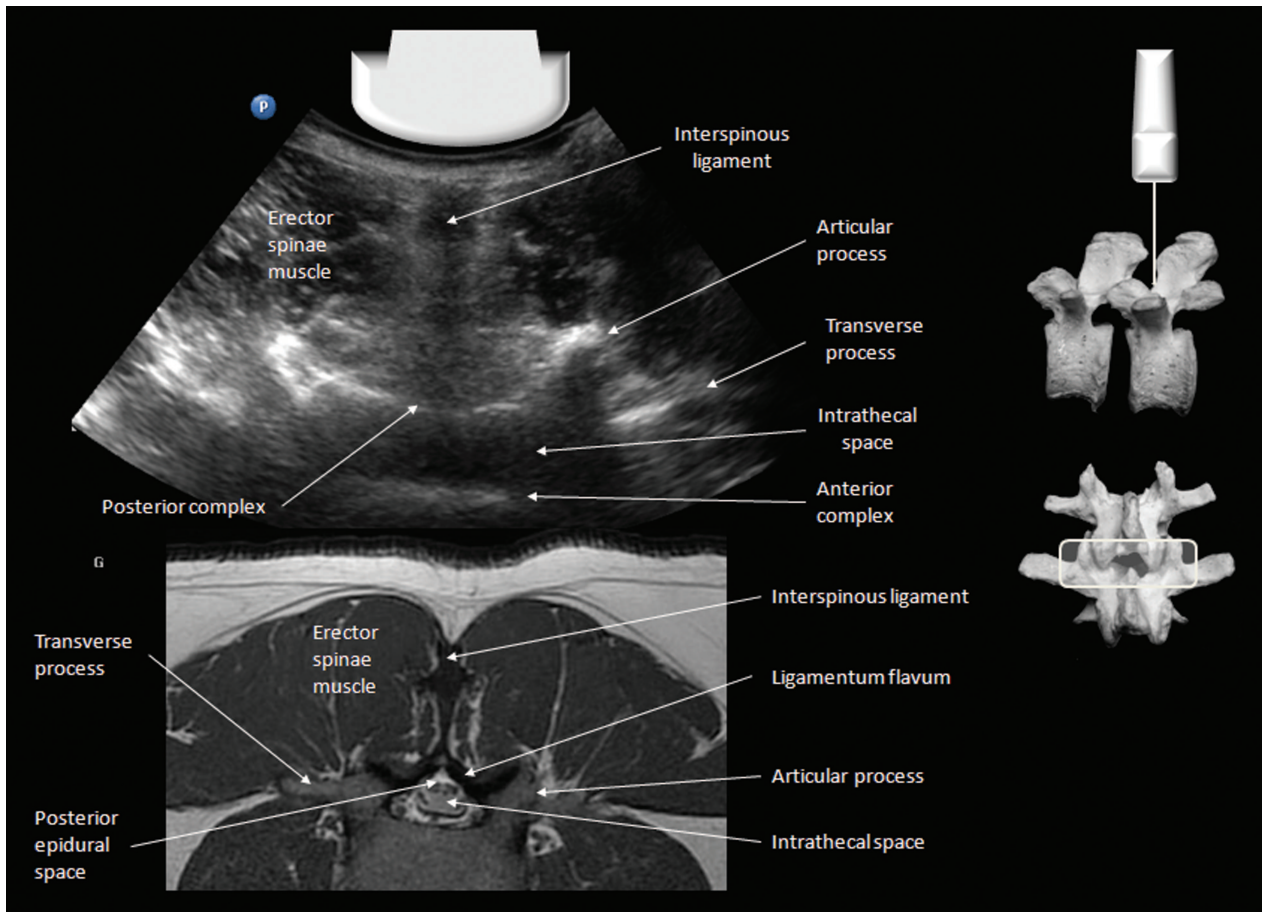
Transverse interlaminar view of the lumbar spine and corresponding magnetic resonance imaging scan (T1-weighted). The intrathecal space is a dark hypoechoic band sandwiched between the hyperechoic posterior and anterior complex. The transverse processes and articular processes lie in the same transverse plane and are usually visible. The ligamentum flavum, posterior epidural space, and dura often cannot be distinguished from one another in the transverse view. The midline is indicated by the dark vertical stripe of the interspinous ligament. (Image used with permission from www.usra.ca.)
